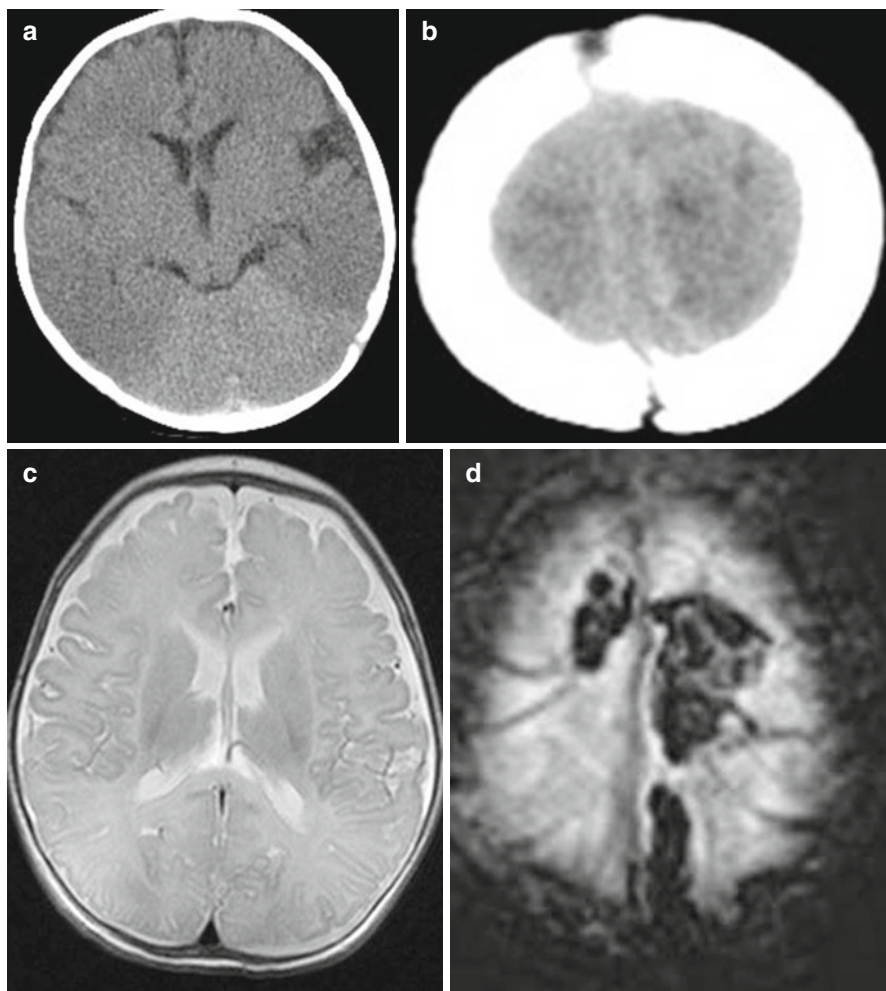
Images from an infant aged 3 months who had an out-of-hospital cardiac arrest. (a) CT shows the reversal sign with lower signal in the cerebrum than the cerebellum and suggests subdural hemorrhages (b) which are more obvious on the T1-weighted image (c), which also shows ischemic change, and on the gradient ECHO image (d). This child had suffered non-accidental injury
